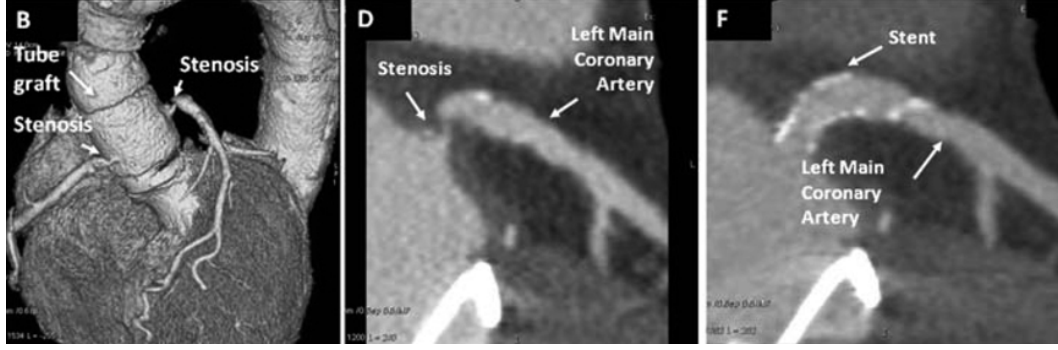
Computed tomography visualization of a stenosed coronary artery before and after stent implantation
